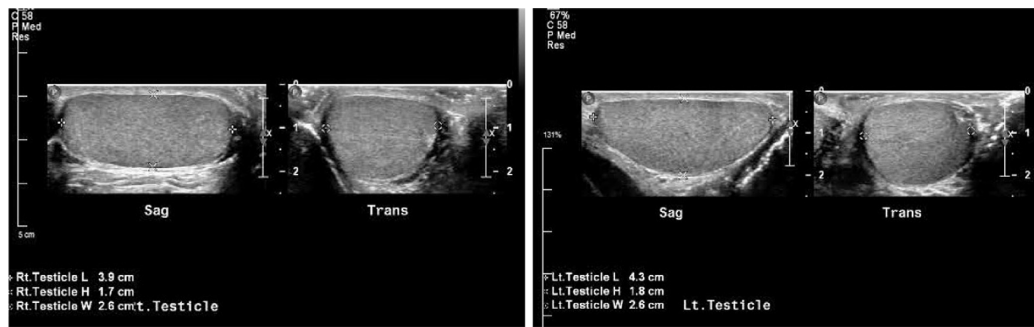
Normal bilateral testicular ultrasound. Note the homogenous testicular echotexture.
